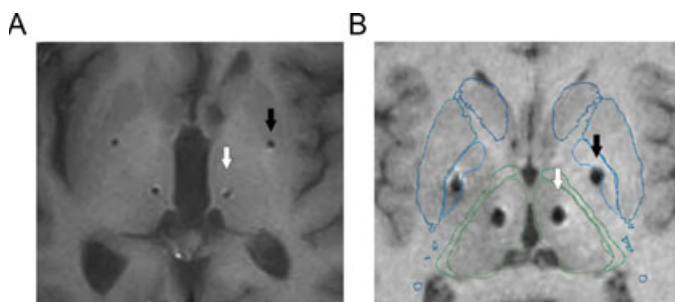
Postoperative MRI scans with axial views of thalamic (white arrows) and pallidal (black) electrodes in (A) the CM/parafascicularis area in subject 11, and (B) the VIM area in subject 4. (B) The atlas of the human basal ganglia by Yelnik *et al.* (2007) is superimposed, confirming electrode localization in the nucleus VIM/MD (contacts 2 and 3) and CM (contacts 0 and 1) on both sides. MD, medial dorsal nucleus.
